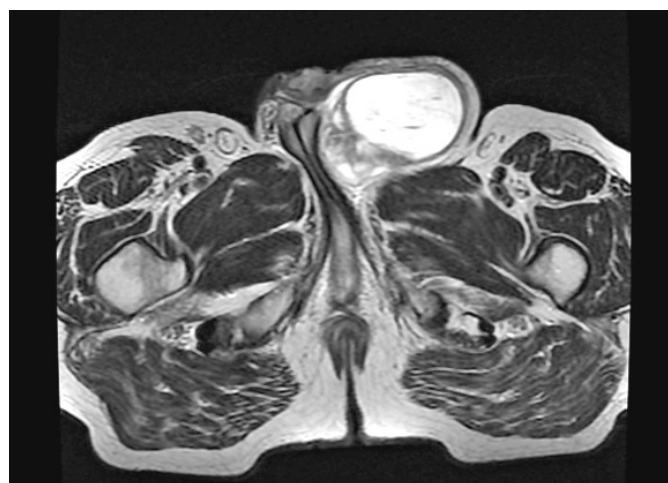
MRI imaging of seroma of the inguinal area. MRI, magnetic resonance imaging.
